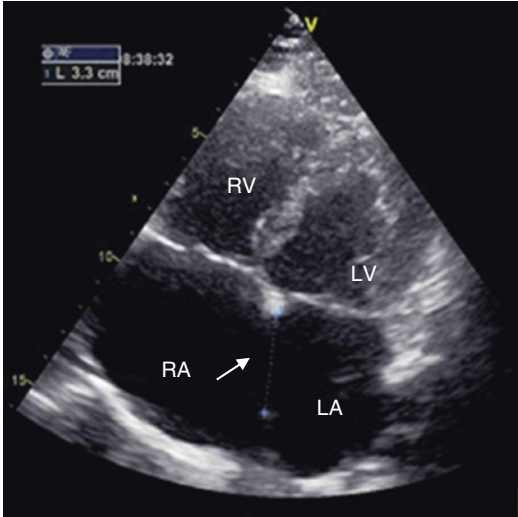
Two-dimensional echocardiogram, apical four-chamber view. There is dilatation and hypertrophy of the right ventricle, that is larger than the left ventricle. A large atrial septal defect (ASD) is present (white arrow). LA left atrium, LV left ventricle, RA right atrium, RV right ventricle
